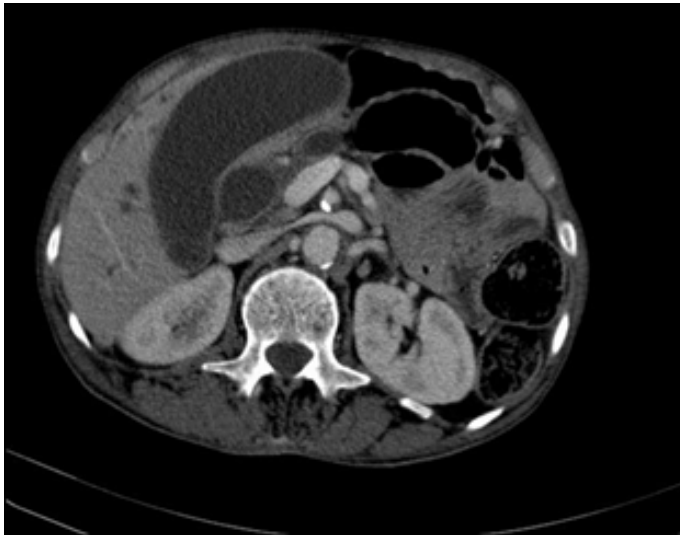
Axial contrast-enhanced computed tomography demonstrating hydroptic gallbladder with transverse diameter more than 40 mm.
